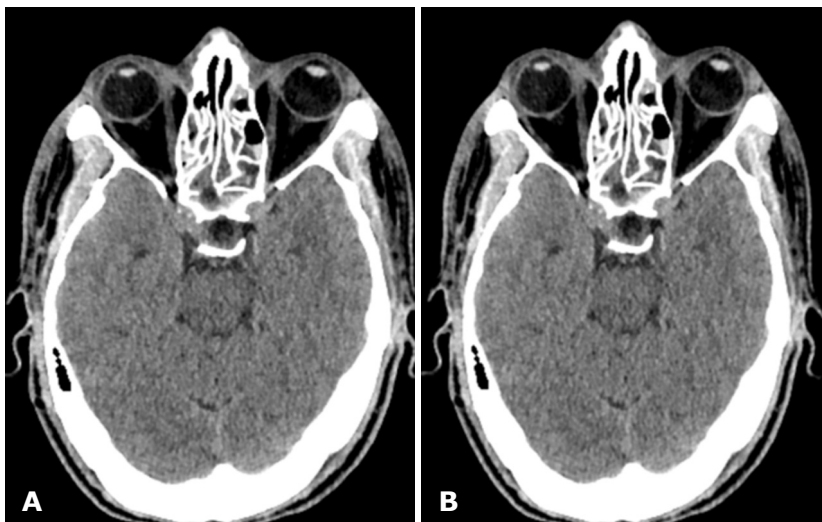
Post operative CT Brain Plain
